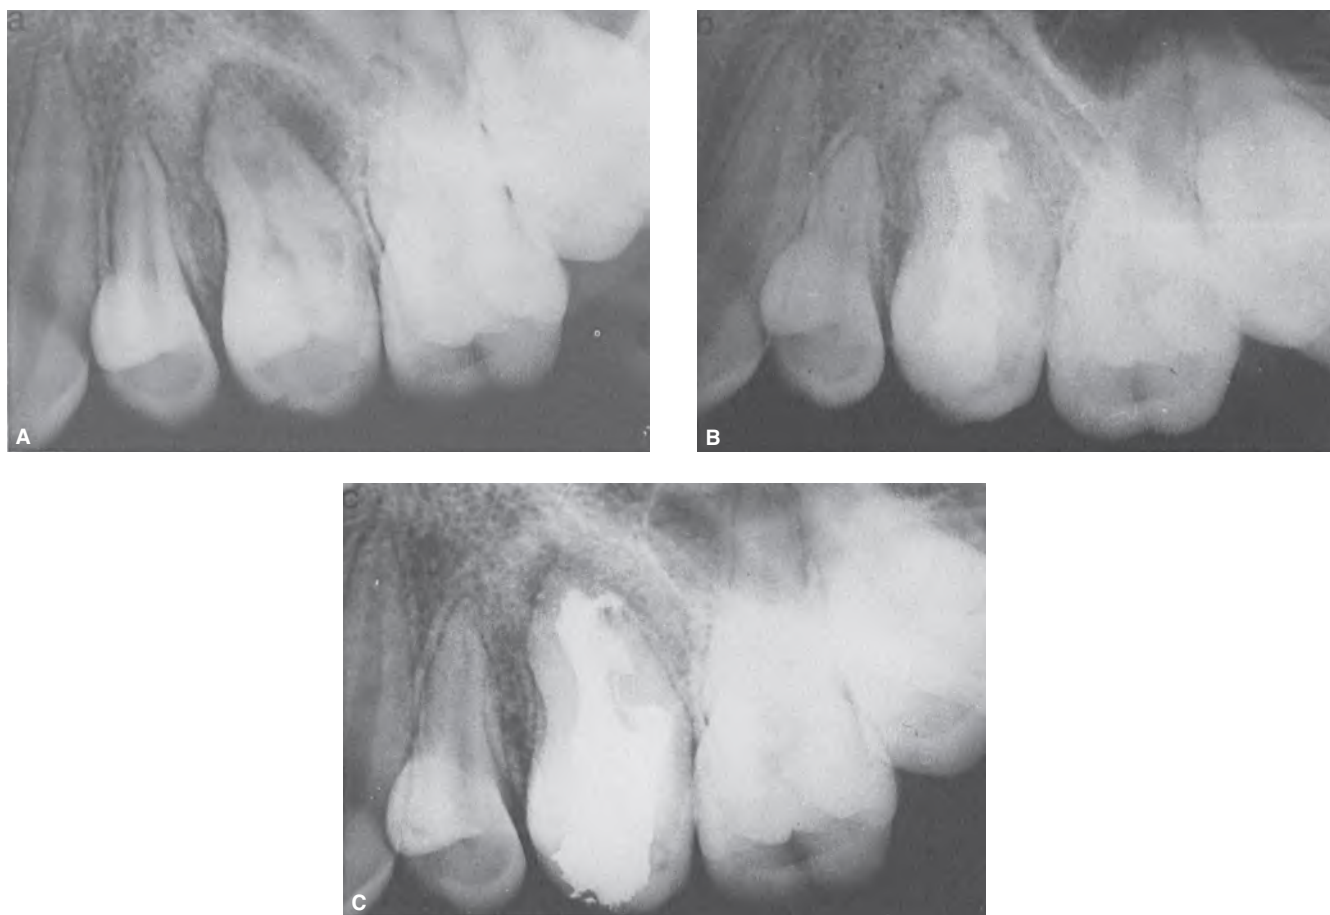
Endodontic therapy of dens invaginatus in a permanent maxillary second premolar of a 14-year-old female. Pulp sensibility tests were negative. A. Preoperative radiograph showing large periapical radiolucency associated with the tooth. B. Six months following introduction of calcium hydroxide to facilitate apical closure. Note considerable reduction in size of the periapical radiolucency. The patient was asymptomatic. C. Postoperative radiograph. The complex root canal system was obturated with softened gutta-percha and sealer. The coronal access was restored. (Courtesy of Dr. Ilan Rotstein, Los Angeles, California. Adapted with permission from Rotstein et al.⁸⁸)
